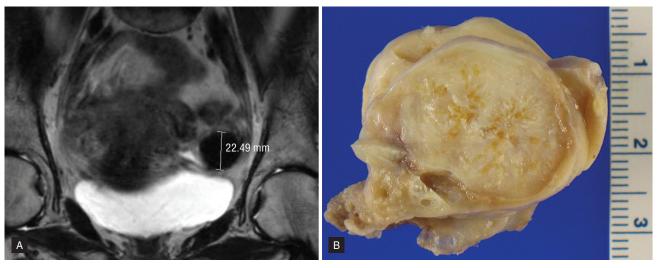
(A) Magnetic resonance imaging of the left ovarian mass that showed homogeneous, low T2 signal and minimal enhancement after the administration of gadolinium. (B) Gross pathology showing the cut surface of the 4-cm ovarian mass.
